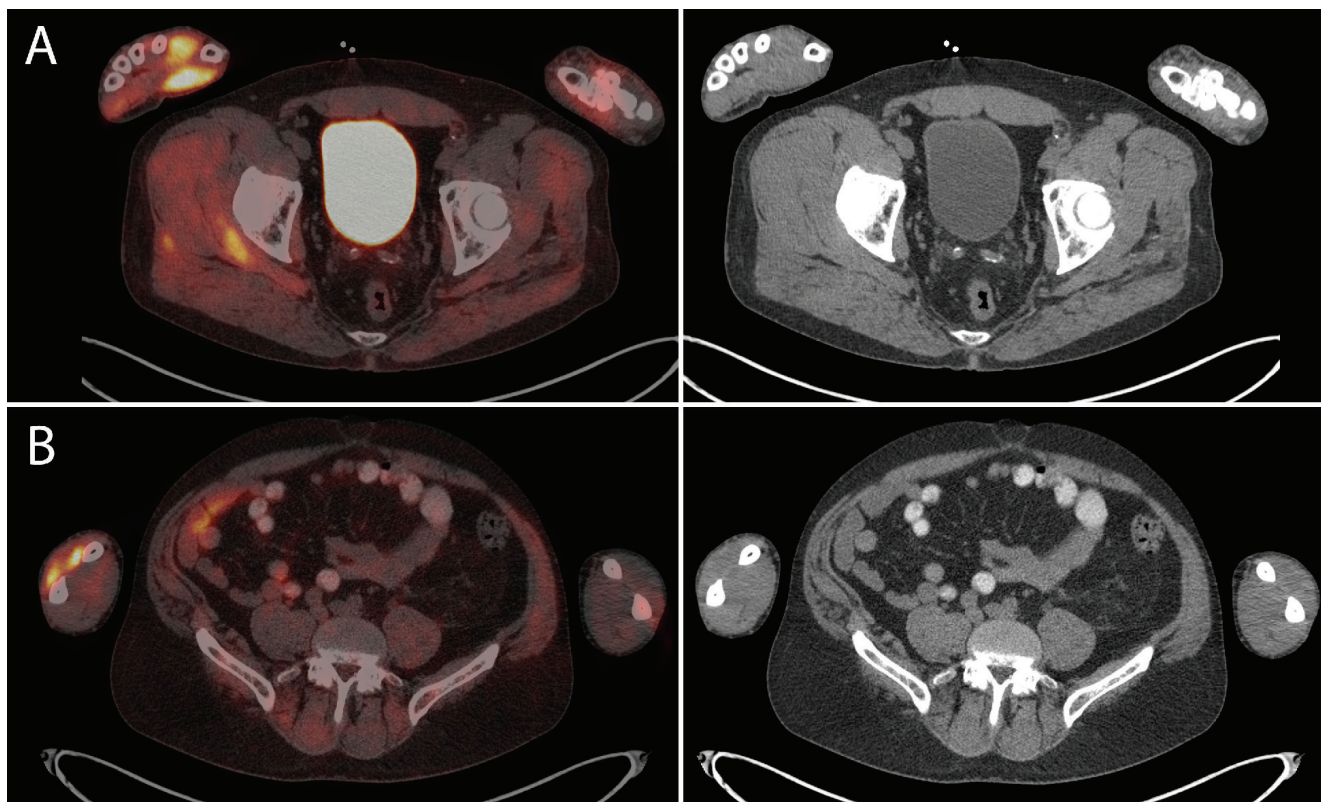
(A) Intense ¹⁸F-FDG uptake in the right thenar eminence with maximum standard uptake value (SUV_{max}) 8.8 was the most intensely ¹⁸F-FDG avid abnormality in the entire PET/CT study, and was most likely the result of the patient holding beer cans and drinking beer. (B) Right dorsal extensor forearm muscles also showed intense ¹⁸F-FDG uptake with SUV_{max} 6.7.
